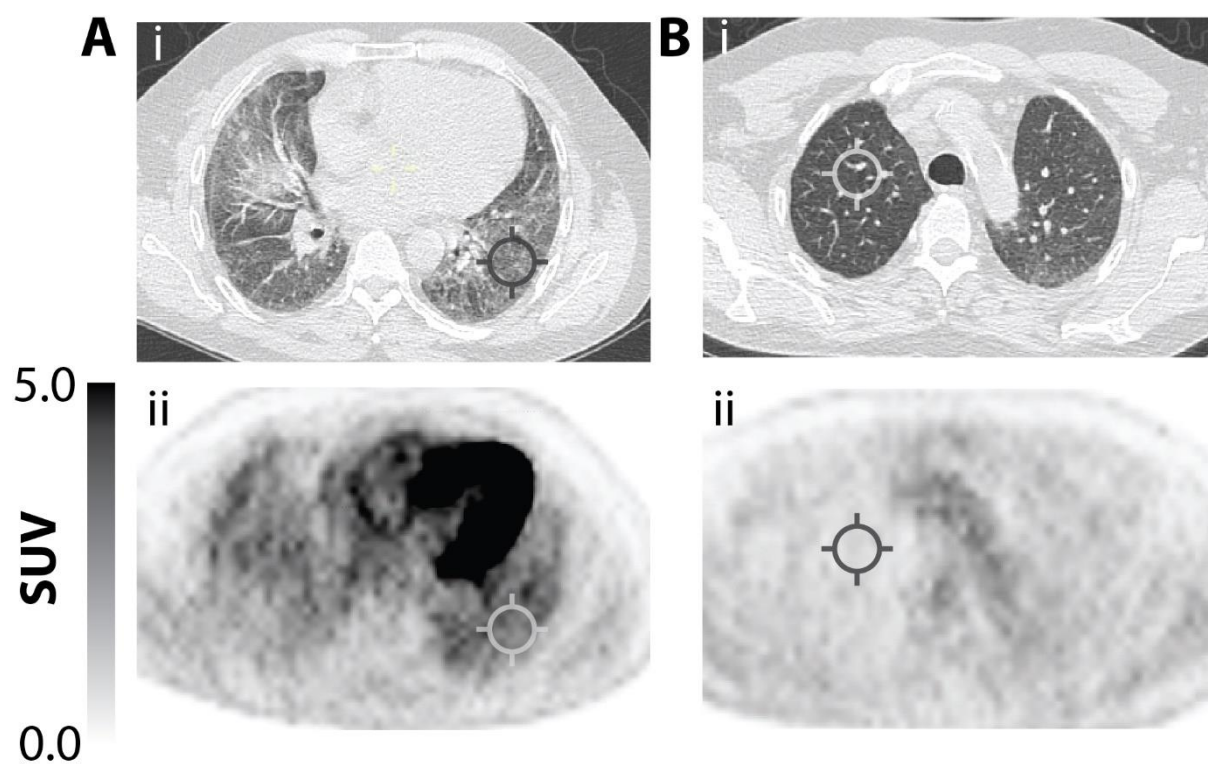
Co-registered i) CT and ii) ^{18}F -FDG PET of a patient with non-specific interstitial pneumonia (NSIP), showing A) region of interest placement measuring maximal pulmonary ^{18}F -FDG uptake (SUV_{max}) and B) background uptake in unaffected lung (SUV_{min}).
